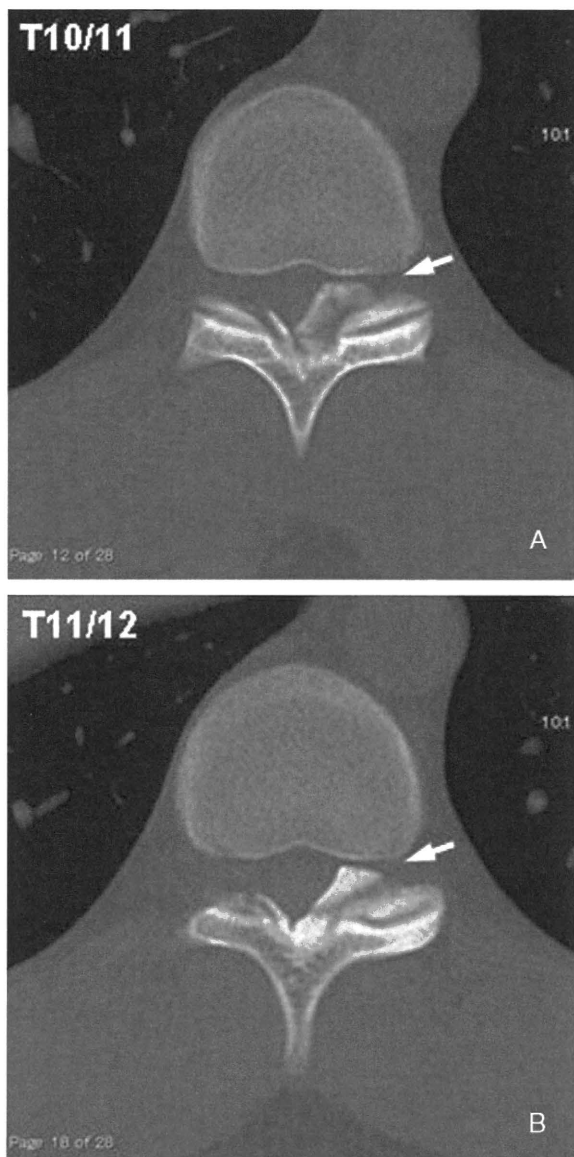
Computed tomography demonstrating the unilateral left-sided ossifications of the yellow ligament are shown at T10-T11 level (A) and T11-T12 (B) (arrows) in patient 2.
